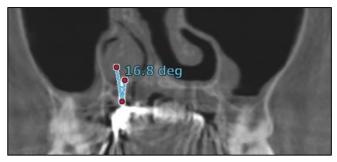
"A°T3" parameter: CBCT image in the coronal plane.
